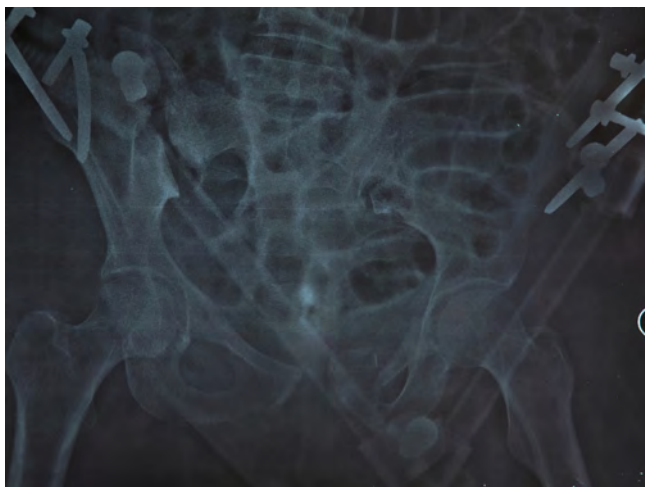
Left ischium pubic branch fracture, right iliac wing fracture, right sacroiliac joint separation (Tile Type C1-2) are seen in X-Ray graph.
